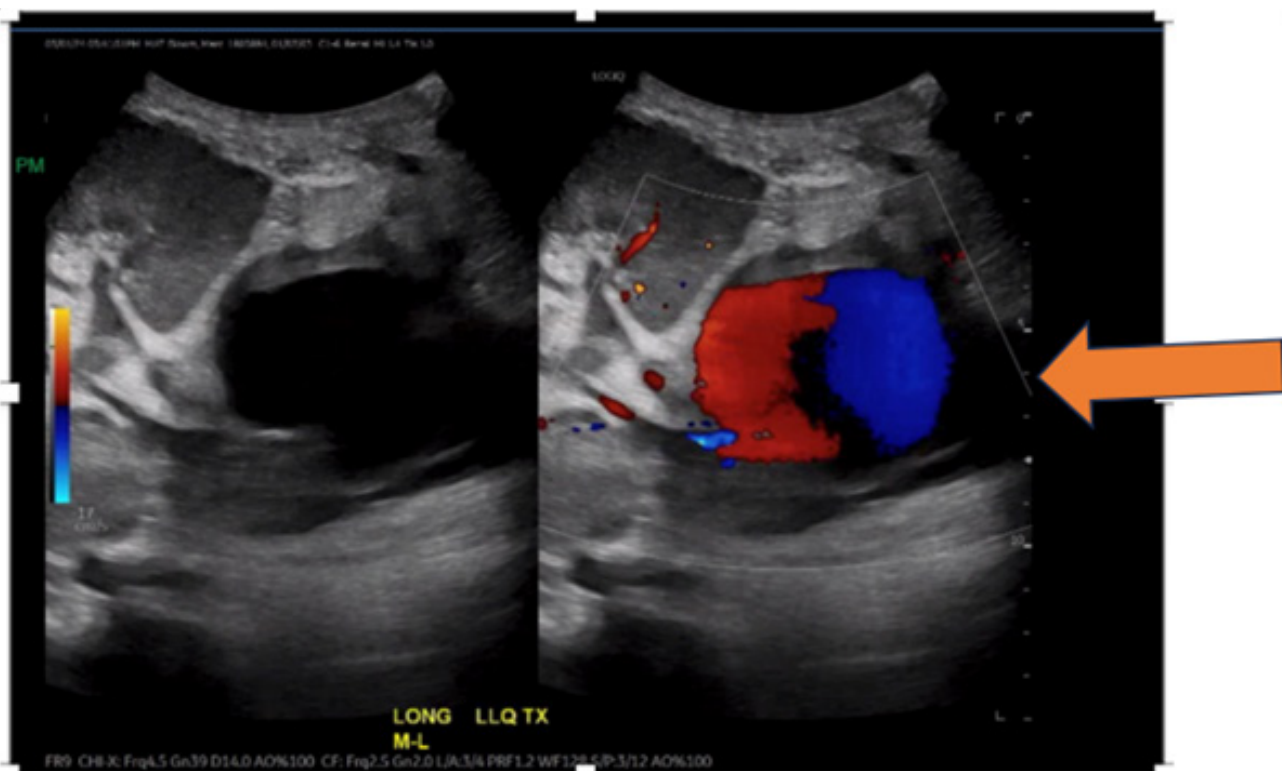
doppler US transplant kidney: thick-walled round fluid collection in the deep iliac fossa inferior to the graft measuring 6cm in diameter with internal arterialized waveform with yin-yang morphology, consistent with pseudoaneurysm.
